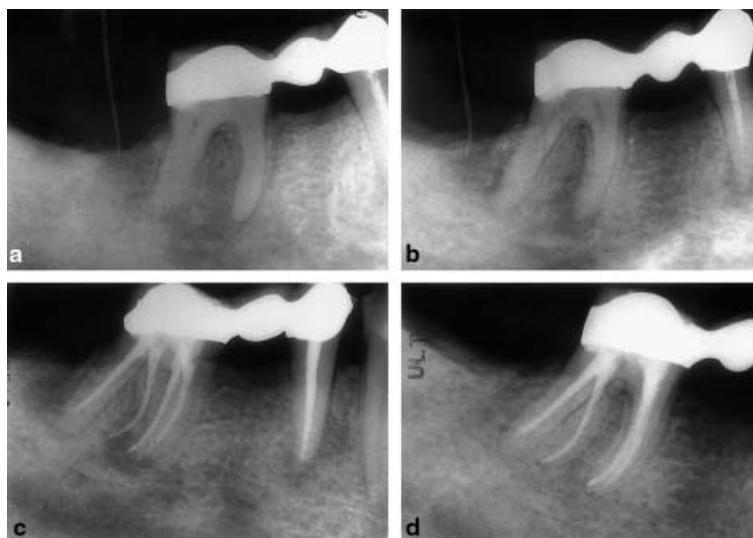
(a) Radiograph of tooth 46 (restored with a ceramic-metal crown and being part of a fixed bridge covering 46-45-44) – tooth 47 had been extracted 6 months earlier. Sinus tract was traced by means of a conventionally tapered gutta-percha size 25. (b) A second preoperative radiograph of tooth 46 taken with a more mesial angulation and revealing the presence of lingually located additional distal root as well as more outlined periapical lesions. (c) Radiographic control following obturation of the four root canals. (d) One-year postoperative radiographic control indicating healthy apical bone structure without radiographic signs of apical periodontitis.
